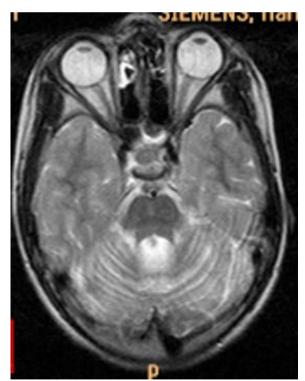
(b): T2W and FLAIR axial images showing atrophy of bilateral cerebellar hemispheres and vermis
